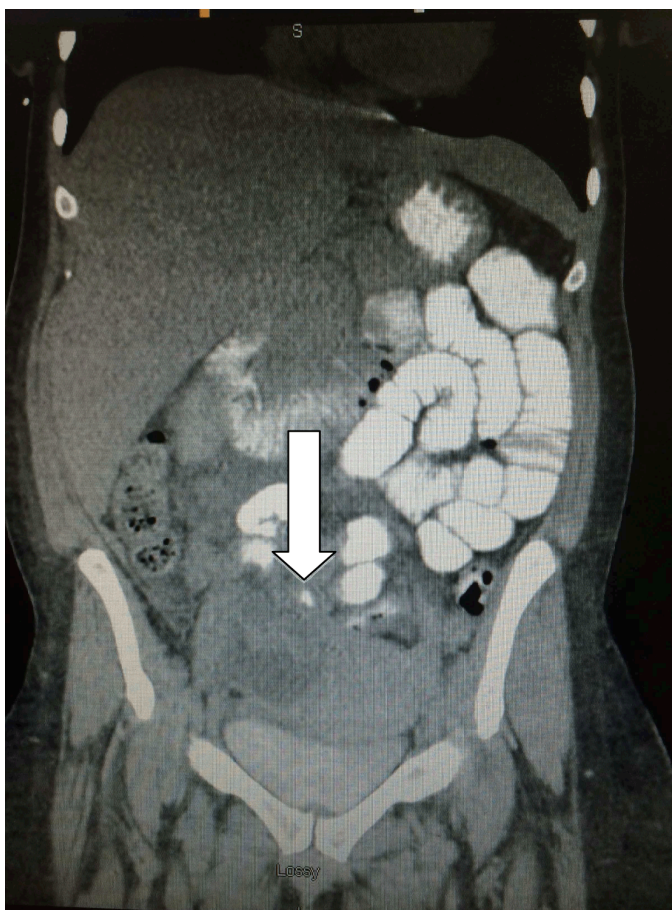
Computed tomography scan of abdomen with and without contrast revealing 6.5x1.5x8.5 cm residual necrotic tumor in the right pelvis as well as mesenteric and retroperitoneal lymphadenopathy consistent with metastatic disease.
